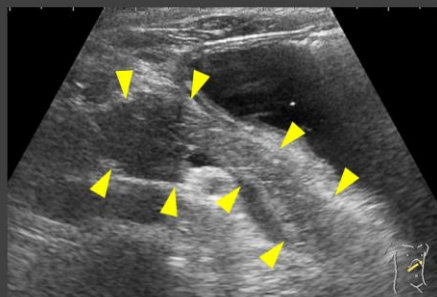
Abdominal ultrasonography revealed diffuse enlargement of pancreas with coarse parenchyma (arrowheads).
